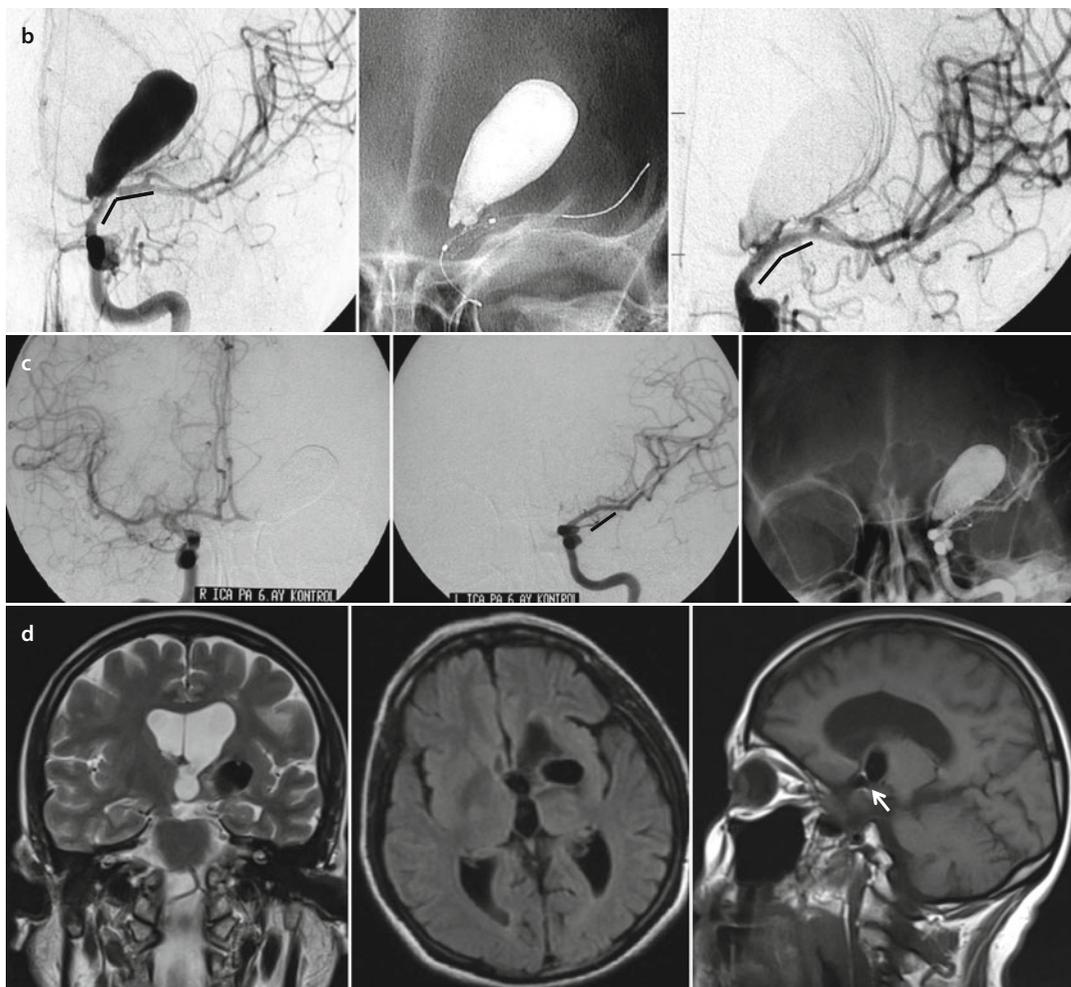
(continued) (b) Cerebral DSA AP view reveals a 31 × 14 mm-sized luminal filling of ICA bifurcation GIA with the ACA arising from the aneurysmal neck. There is displacement of the lateral lenticulostriate arteries and ACA. Also note the ICA to MCA angulation. On February 2001, the aneurysm was occluded using Onyx 500 HD® with a coronary BMS (AV 670; Medtronic, Santa Rosa, CA, USA) 2.5 × 9 mm deployed at the ICA termination covering the ACA origin with flow diversion of ICA flow into MCA. There is minimal residual filling of the aneurysmal neck. The rigid coronary BMS intentionally changed the angulation of ICA bifurcation (*the lines depict the carotid bifurcation angulation*). This in effect resulted in filling of the left ACA by flow reversal from the ACoM. This was done as the aneurysmal neck incorporated the A1 segment of left ACA. Posttreatment DSA and fluoroscopic images show a changed ICA bifurcation angulation and hemodynamic conversion of a terminal bifurcation aneurysm to a sidewall aneurysm. The left ACA is opacified from the opposite ICA. (c) On a 6-month and 1-year control angiograms, there is stable aneurysmal occlusion, patent stented segment, and left ACA filling through ACoM via flow reversal. (d) A posttreatment patient made gradual but full recovery over a period of 1 month. On 13-year follow-up, MRI reveals stable aneurysmal occlusion, decreased mass effect, and no peri-aneurysmal gliosis. Also, note that the onyx does not produce any imaging artifact on FLAIR, T2W, and T1W images. *Arrow* depicts artifact due to the coronary stent
